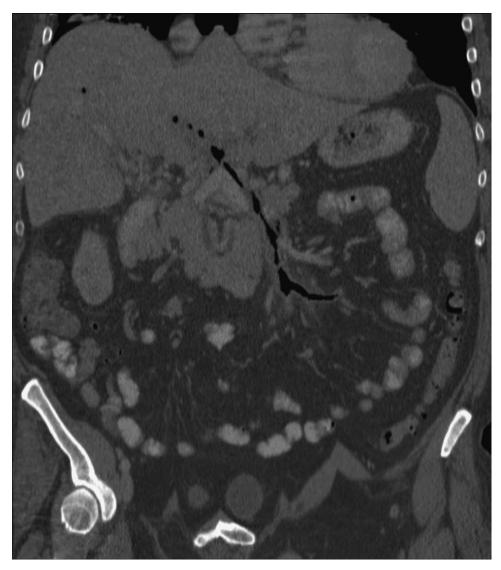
Multiplanar reconstruction of abdominal computed tomography scan, showing intrahepatic, portal venous, and superior mesenteric venous gas in a 52-year-old patient with ongoing sepsis.
